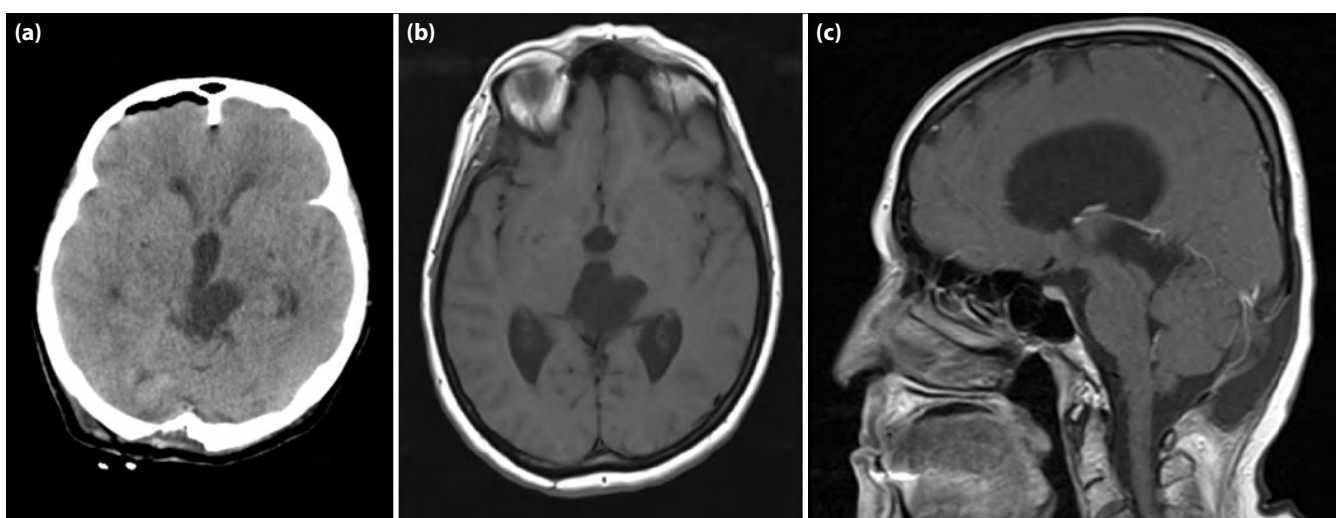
Preoperative computed tomography scan demonstrating an isodense lesion with CSF in the area of quadrigeminal cistern (a). Axial T1- weighted (b), T2- weighted (c), sagittal (d), coronal (e) MRI revealed 50x25 mm cystic mass, isointense with CSF on T1- and T2- weighted images, causing severe compression on the aqueduct of Sylvius, posterior third ventricle and mesencephalon from left lateral side, associated with hydrocephalic enlargement of ventricles. extending from superior to the anterior of the cerebellum, displacing the pons anteriorly and superiorly.
